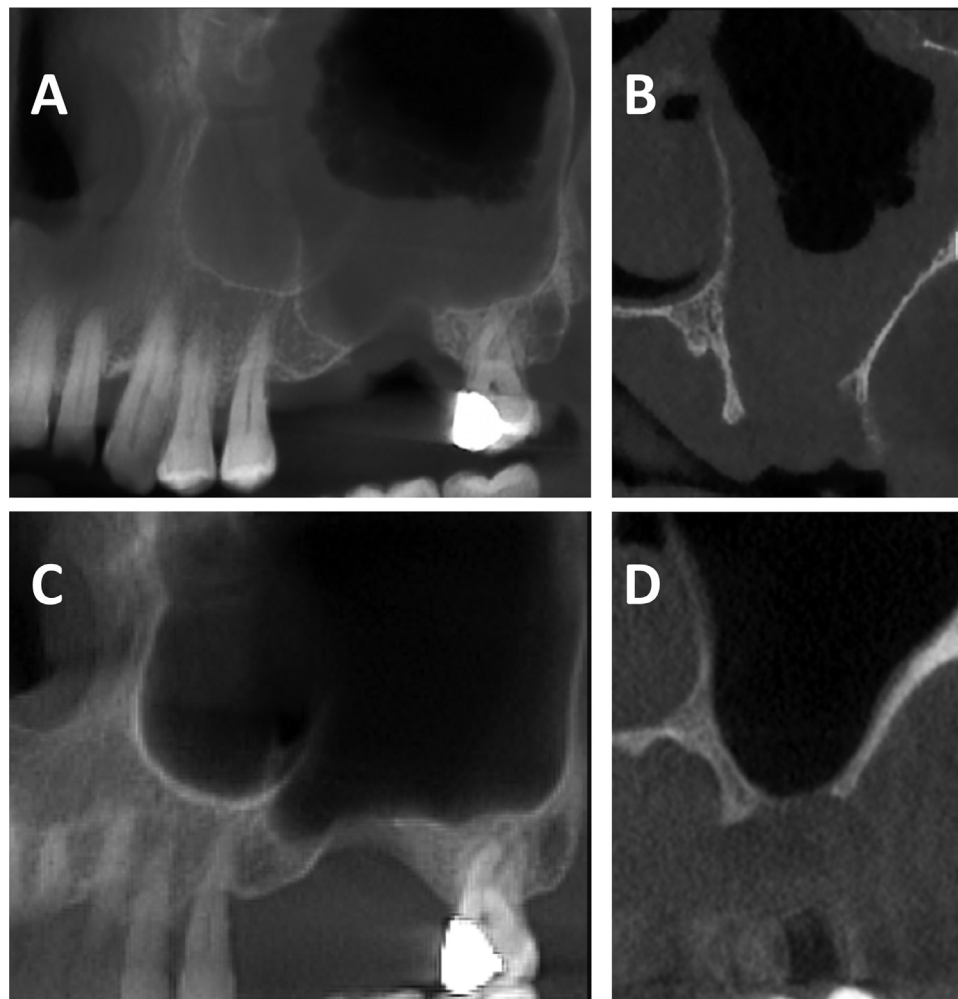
(A, B) Panoramic and para-axial reconstructions of cone beam computed tomography (CBCT) of left maxilla demonstrating a bone defect in the antral floor and thickening of the sinus mucosa. After closure of the oroantral fistula (OAF), the bony defect in the antral floor is still present, but the sinus lining the mucosa is thin and healthy.
